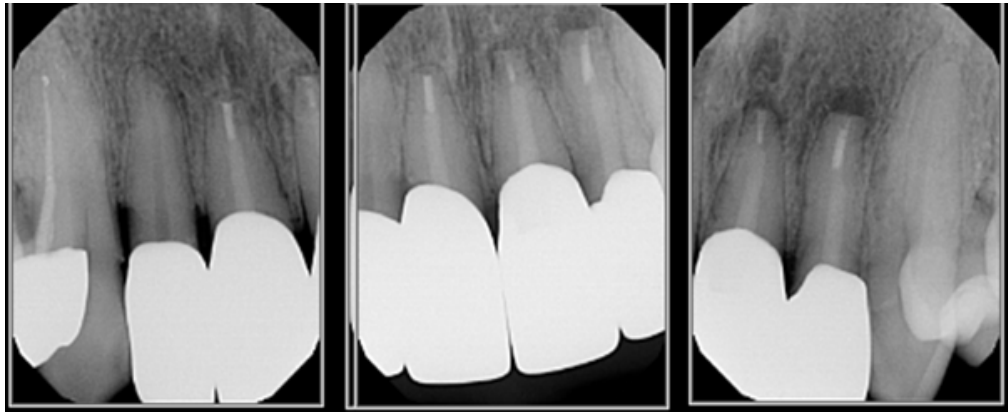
Post-cementation radiographs.
